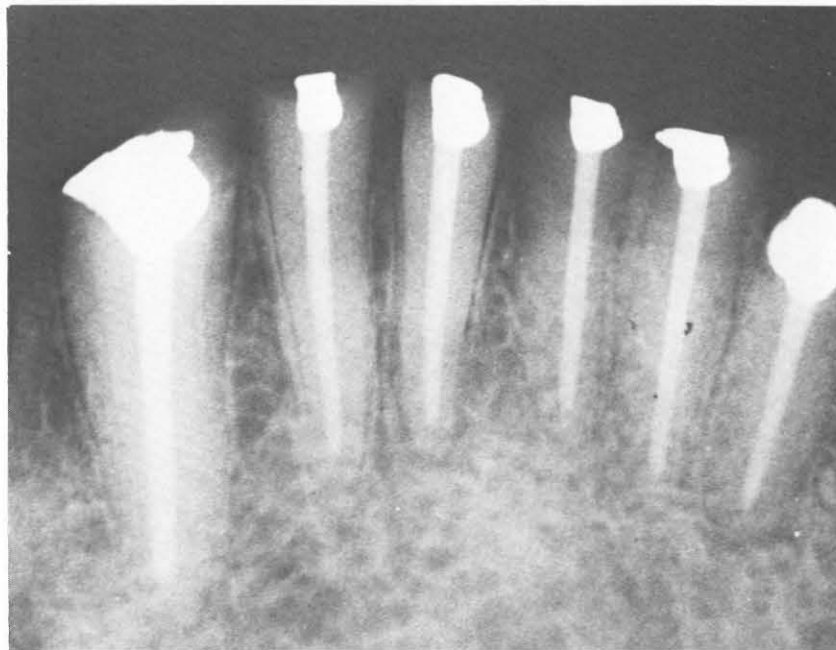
1-year followup radiograph
